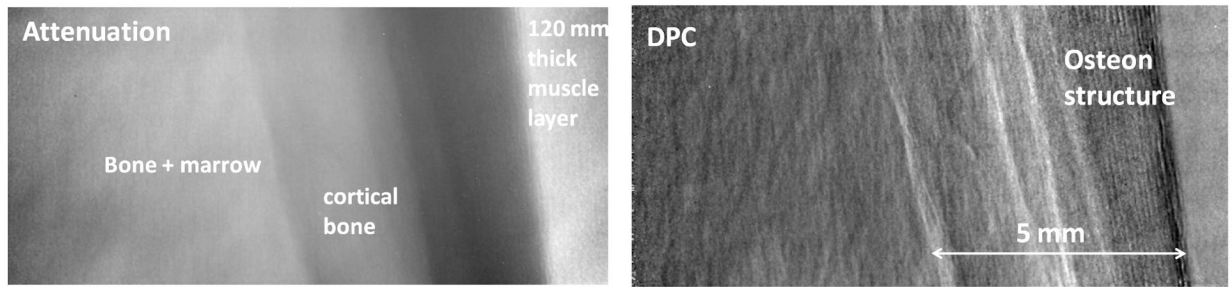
80 kVp attenuation and DPC radiographs of a fresh veal leg of ~120 mm thickness, containing a ~40 mm diameter bone with 4–5 mm thick cortical bone layer.
